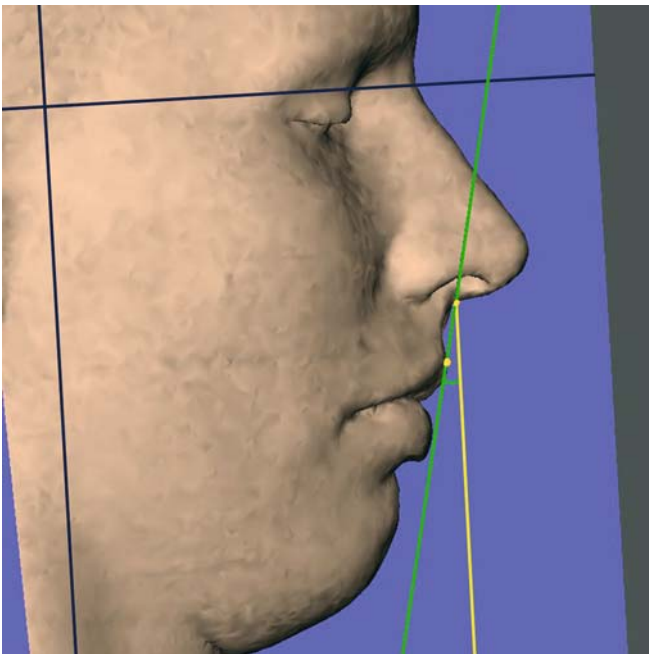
The inclination of the upper lip from the vertical plane, $sn-ls / y$ -plane, is a projected angular soft tissue measurement on the median (z) 3-D cephalometric reference plane (3-D CT, soft tissues, patient K.C.)
